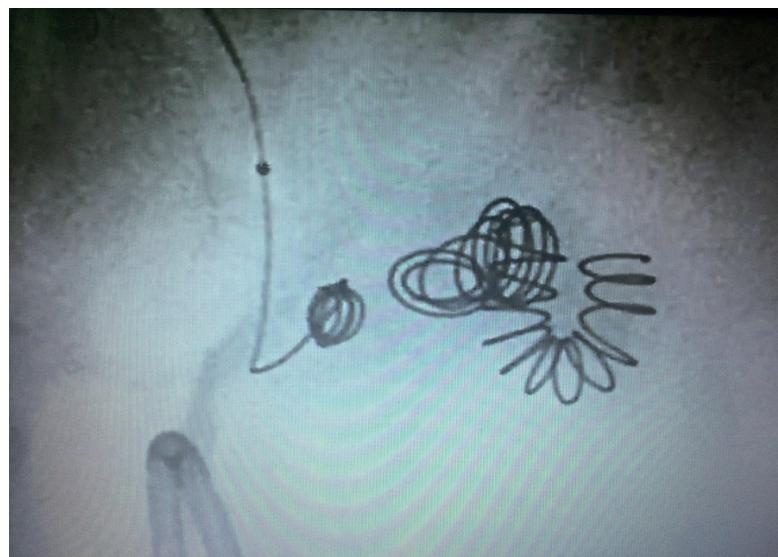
X-ray image of the stent and coils, introduced into the aneurysm cavity for it's shutoff.
